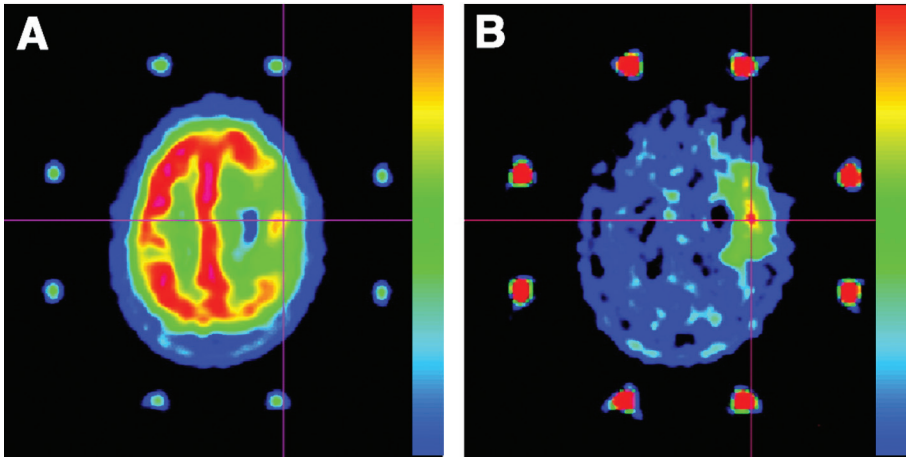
PET performed with ^{18}F -FDG (A) and ^{11}C -MET (B) in a 62-year-old woman with a glioblastoma in the left prerolandic cortical area. Uptake of ^{18}F -FDG was reduced in the tumor area except for one area of uptake equivalent to that in the surrounding gray matter. Uptake of ^{11}C -MET was higher in the tumor than in the surrounding cortex, allowing the definition of a target for biopsy. When PET images obtained with the two tracers were co-recorded, the highest focus of ^{11}C -MET uptake corresponded to the hot spot of ^{18}F -FDG uptake (intersecting lines). (Adapted from *J Nucl Med* 2004;45:1293–1298. Copyright: The Society of Nuclear Medicine and Molecular Imaging, Inc. Reproduced with Permission.)
